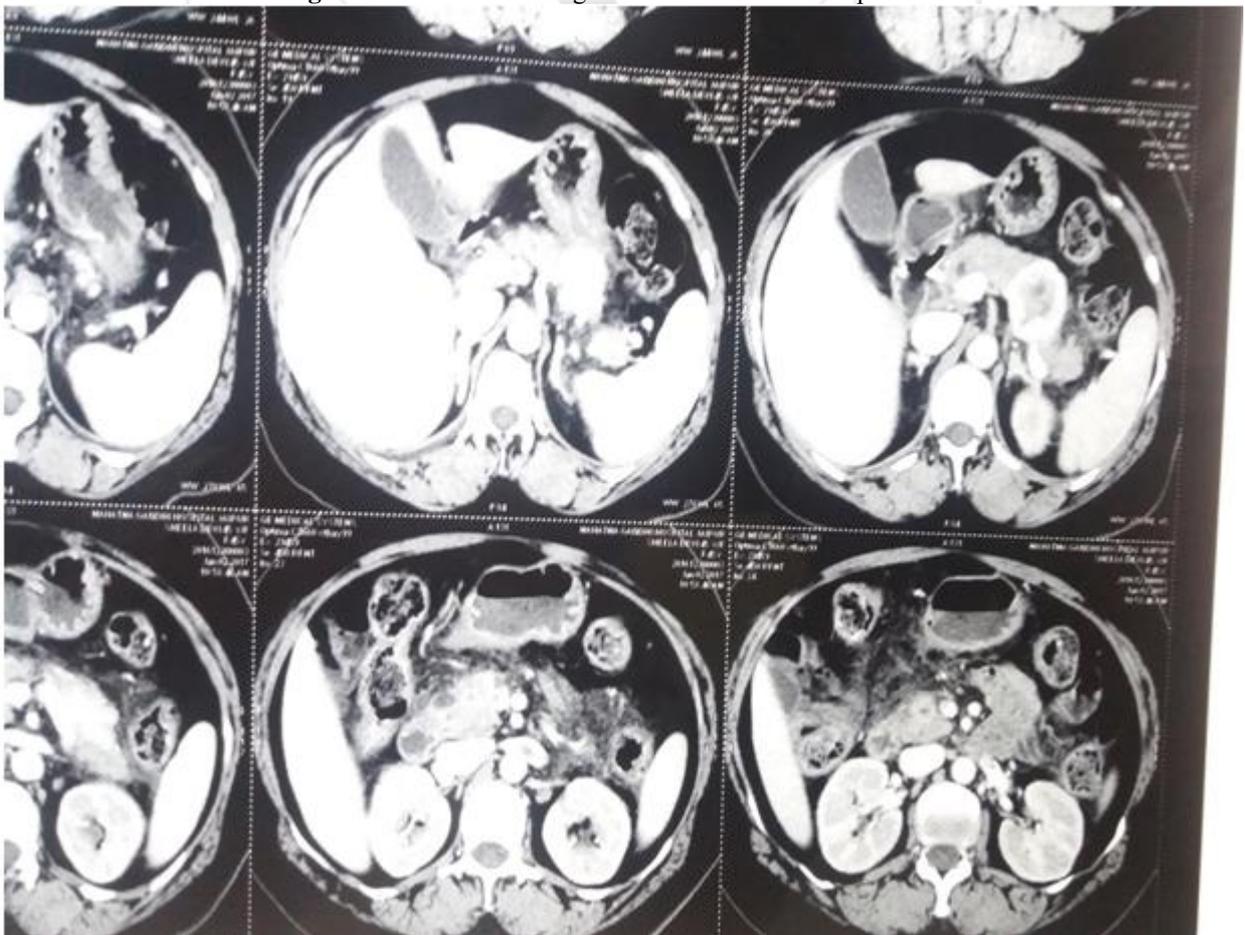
CT Scan showing insulinoma in the tail of pancreas.
